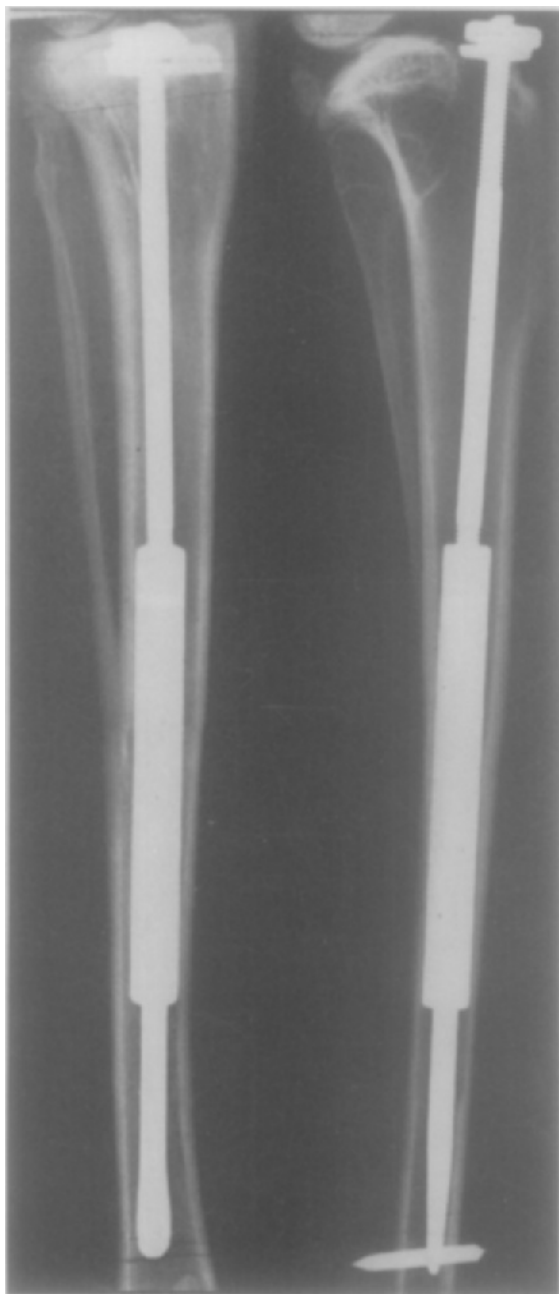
X-ray appearance just after operative procedure.
